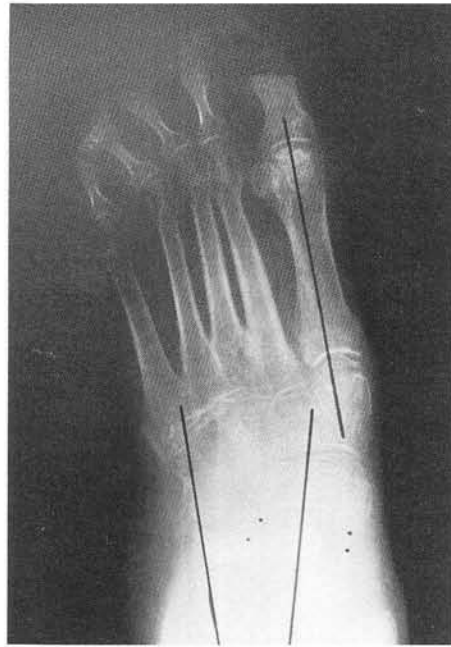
Dorsoplantar weight bearing radiographs taken several months postoperatively. Note the excellent correction of the peritalar subluxation shown in figure 3A.
